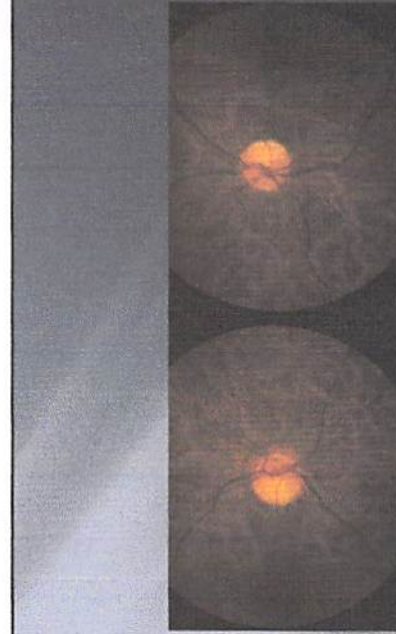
The fundus of the left eye shows a pale optic disc, a normal cup-to-disc ratio, and normal retinal vessels. The fundus of the right eye shows a normal optic disc, a normal cup-to-disc ratio, and normal retinal vessels. Contrast-enhanced magnetic resonance imaging (MRI) of the paranasal sinuses area is shown (Figure 2).
